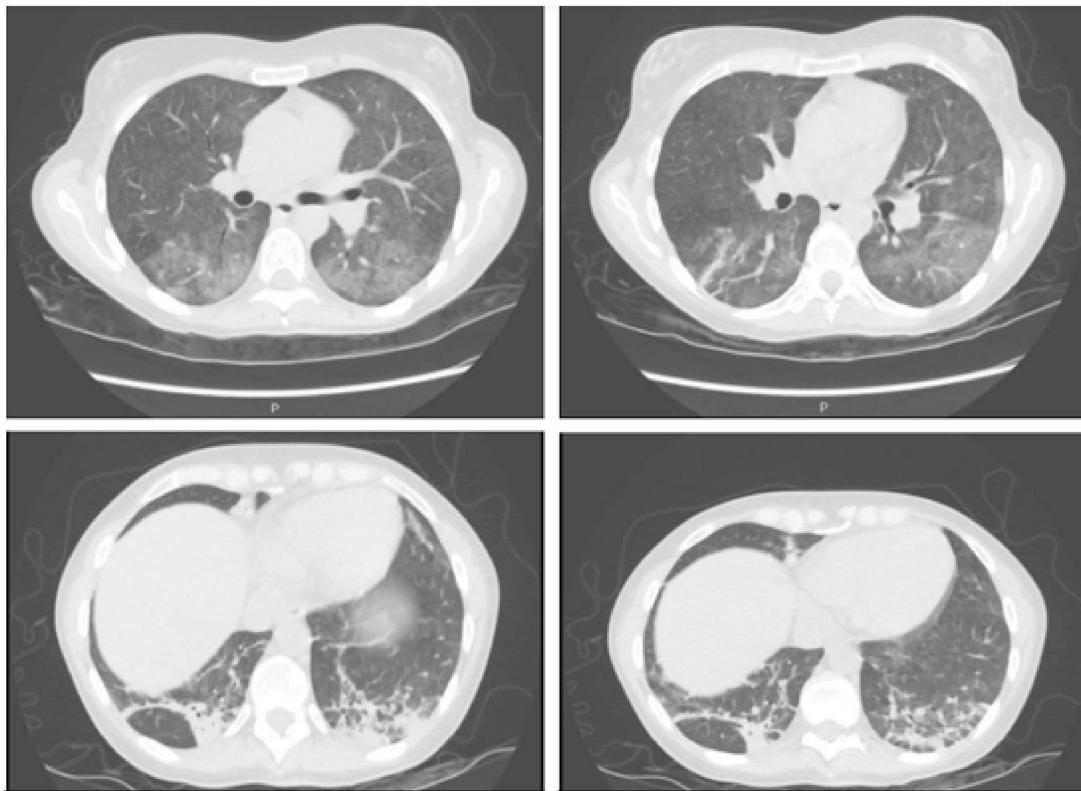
Pulmonary high-resolution computed tomography: infiltrate predominating in both lung bases and left basal pneumonia.
